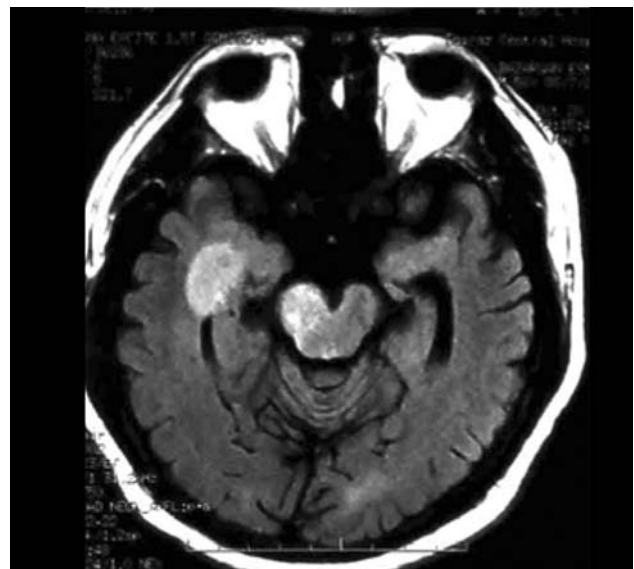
Axial brain MRI FLAIR images showing two separate hyperintense lesions, one at the right medial temporal lobe and another at the right cerebellar peduncle.
